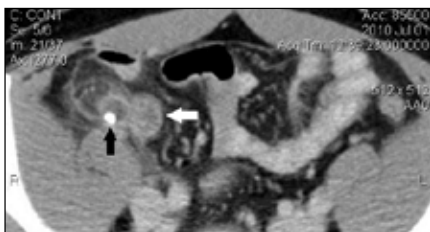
CT showing a thickened and distended appendix (black arrow) containing a faecolith and also showing surrounding peritoneal fat confirming acute appendicitis. Inflammation has extended to the adjacent distal ileal loop (white arrow).
